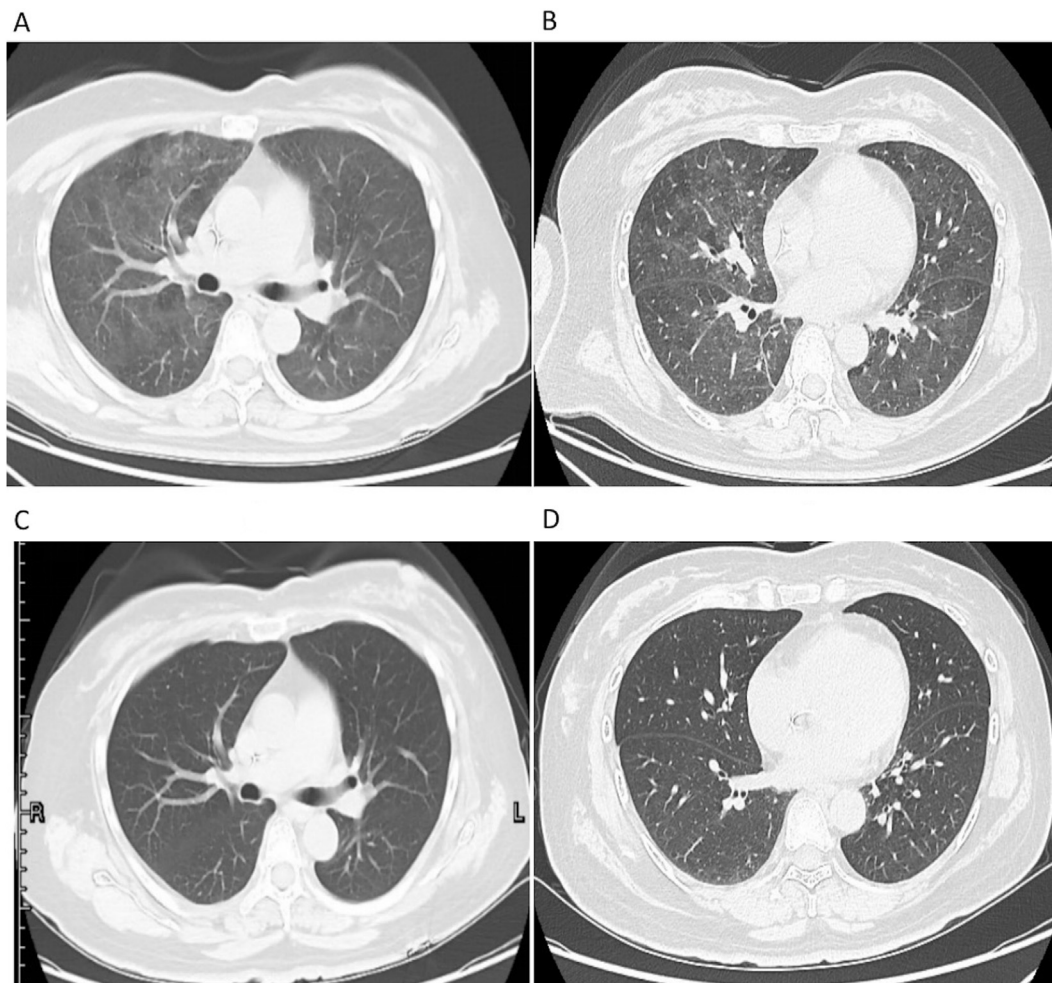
The lung-CT comparison before and after “full coverage” treatment. (A) and (B) show the period of IP, while (C) and (D) show the complete recovery of the lungs after treatment and the disappearance of inflammatory changes. IP: Interstitial pneumonia.
